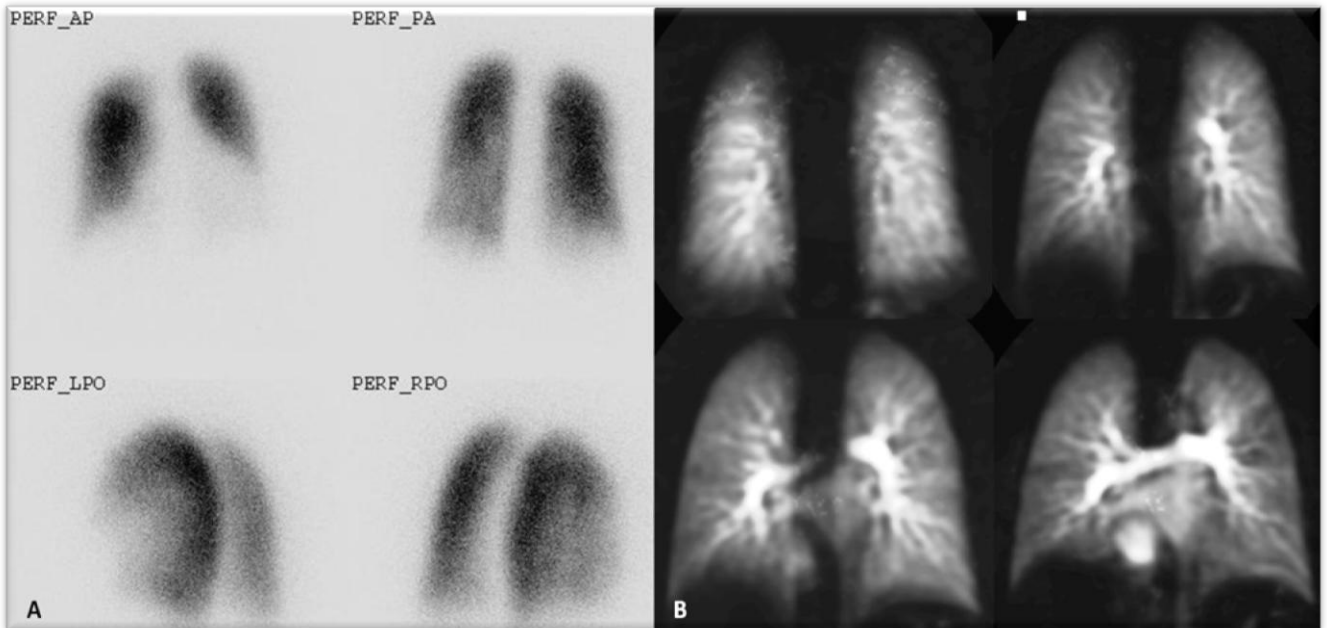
Example of a patient with normal lung perfusion on perfusion scintigraphy (A) and coronal representative MR perfusion images (B)
